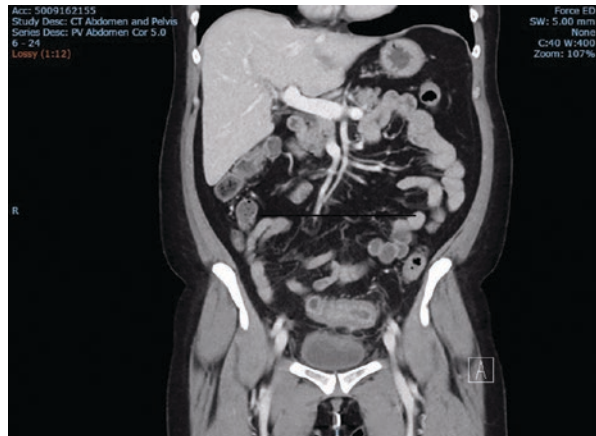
CT scan of complicated acute diverticulitis (patient TB—day 3)
